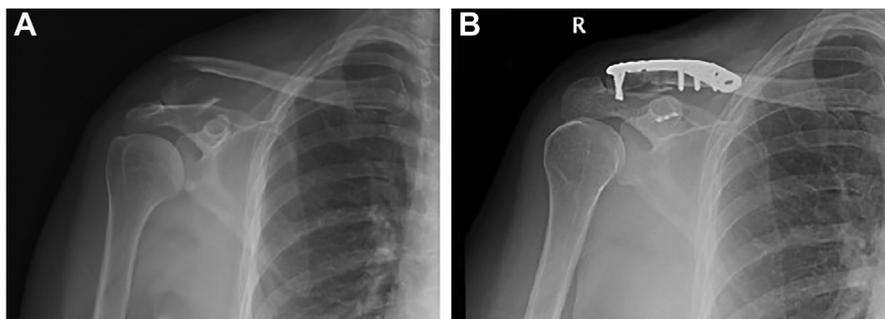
Case example of displaced distal clavicle fracture treated with a locking plate and CC Fixation. (A) Radiograph of an acute distal clavicle fracture with > 100% displacement and a separate inferior clavicle fragment containing the CC ligament insertions. The lateral fragment measured 15 mm. (B) 3 month post-operative radiograph demonstrating fracture union.
